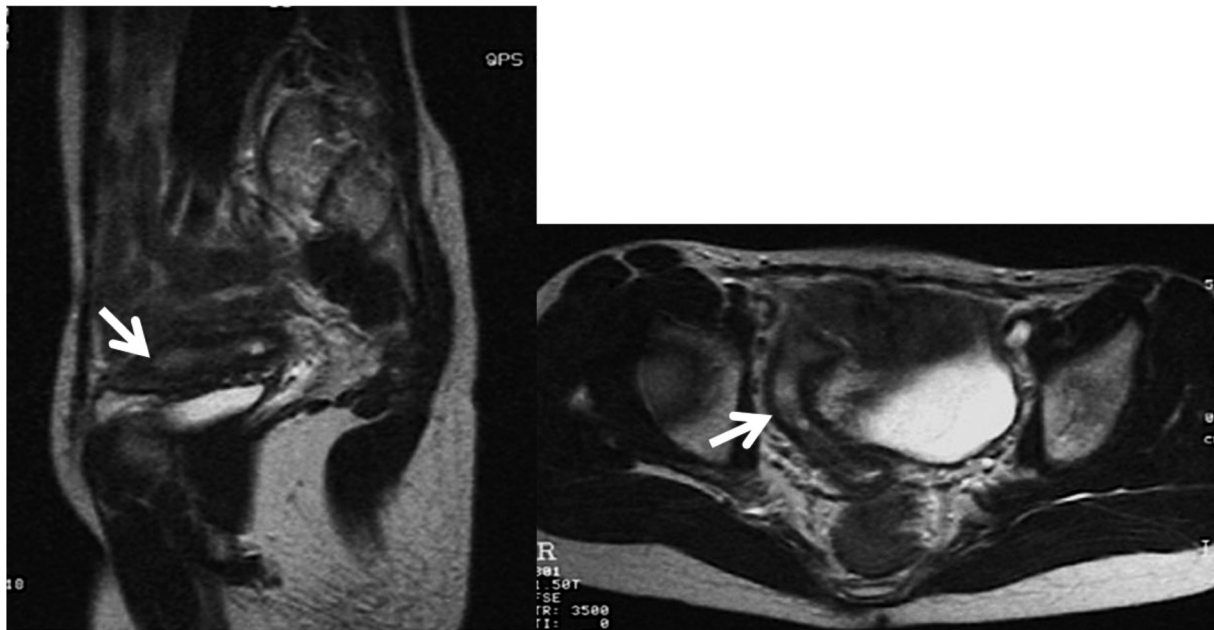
Identification of the uterus using MRI. The patient underwent an MRI due to irregular vaginal bleeding starting at 16 yr of age. The presence of a uterus (arrow) was confirmed for the first time.
